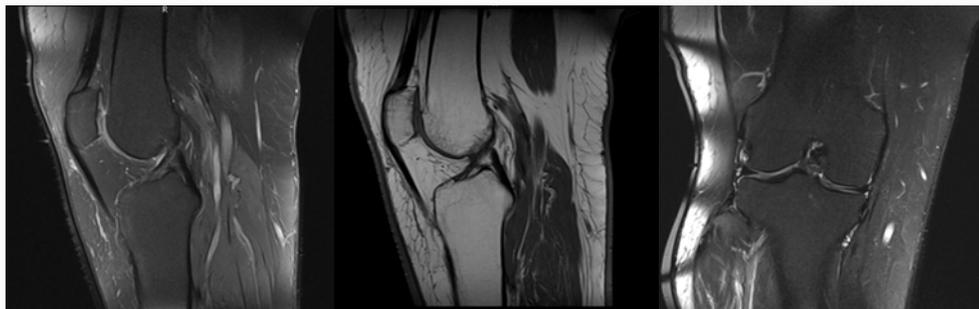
MRI assessment of the patient where an ACL rupture is described. No other interarticular lesions were notified.
